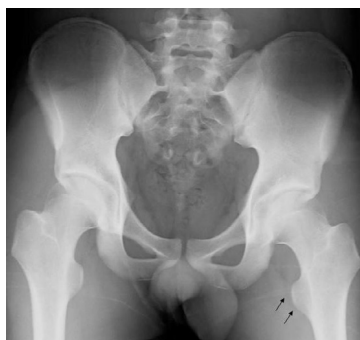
Antero-posterior view of Hip radiograph. There is no evidence of bone fracture in the left lesser trochanter (arrows).
